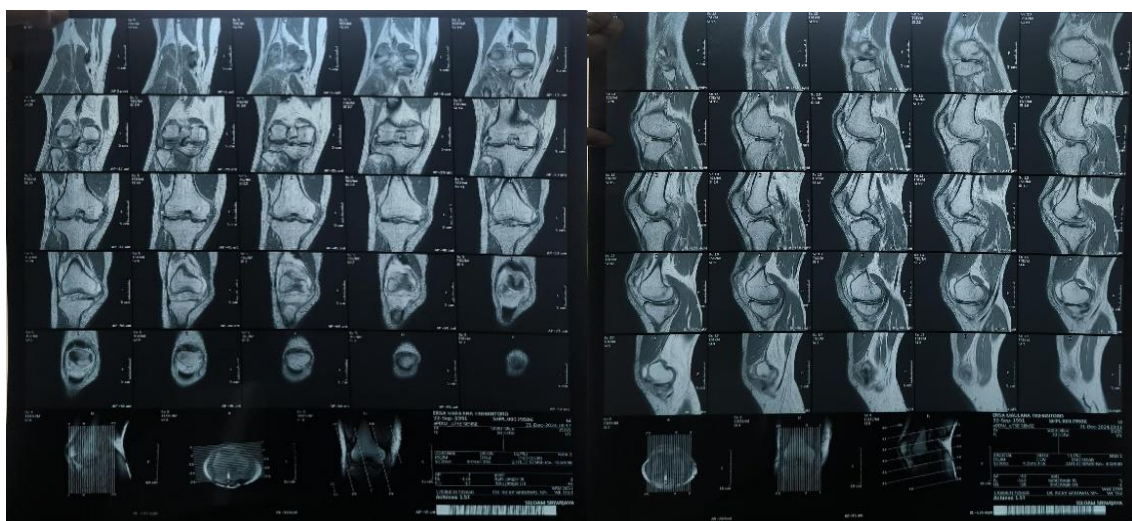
Preoperative MRI of the knee showing complete ACL tear with associated internal derangements
